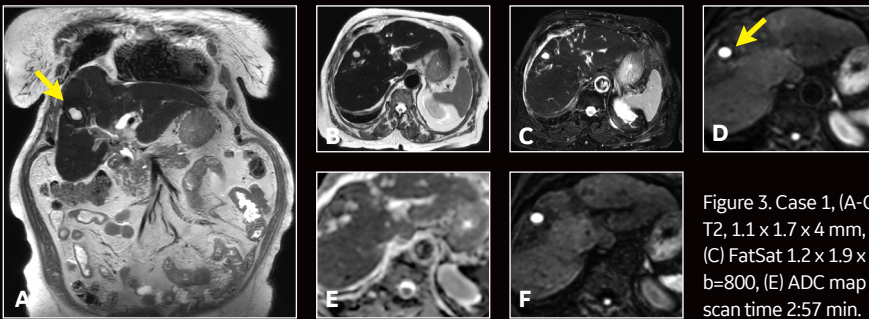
Case 1, (A-C) SnapShot SSFSE with AIR™ Recon DL. (A) Coronal T2, 1.1 x 1.7 x 4 mm, 1:31 min., (B) axial T2, 1.2 x 1.9 x 5 mm, 1:39 min. and (C) FatSat 1.2 x 1.9 x 5 mm, 1:39 min. (D) Axial DWI with Auto Navigator, b=800, (E) ADC map and (F) MAGIC DWI b=1500; (D-F) acquired with total scan time 2:57 min.
